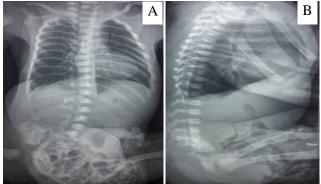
Thoracic-abdominal panoramic radiography (A - anteroposterior; B - lateral to the right): appearance of aerated intestinal loops located in the embryonic sac in a newborn with omphalocele
